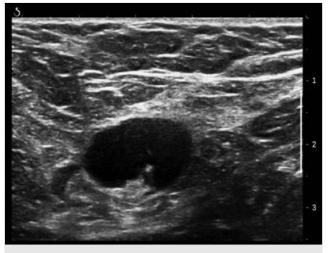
Metastatic lymph node in patient with breast cancer. At B-mode ultrasound, the lymph node presents a thicker and hypoechoic cortex with tiny hilum.
